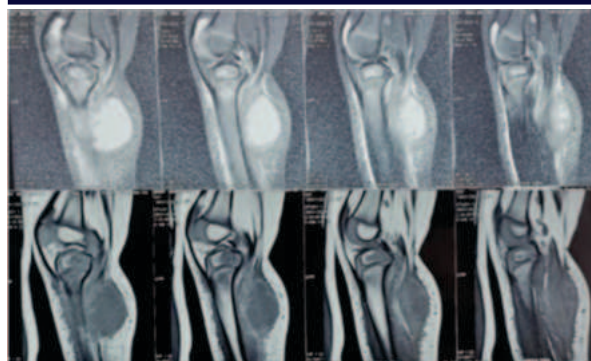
MRI (T1 and T2) sagittal plane of left knee showing soft tissue thickening, periosteal reaction and medium sized fluid collection/abscess of approximate size 4x4x3.8cm, 30ml
